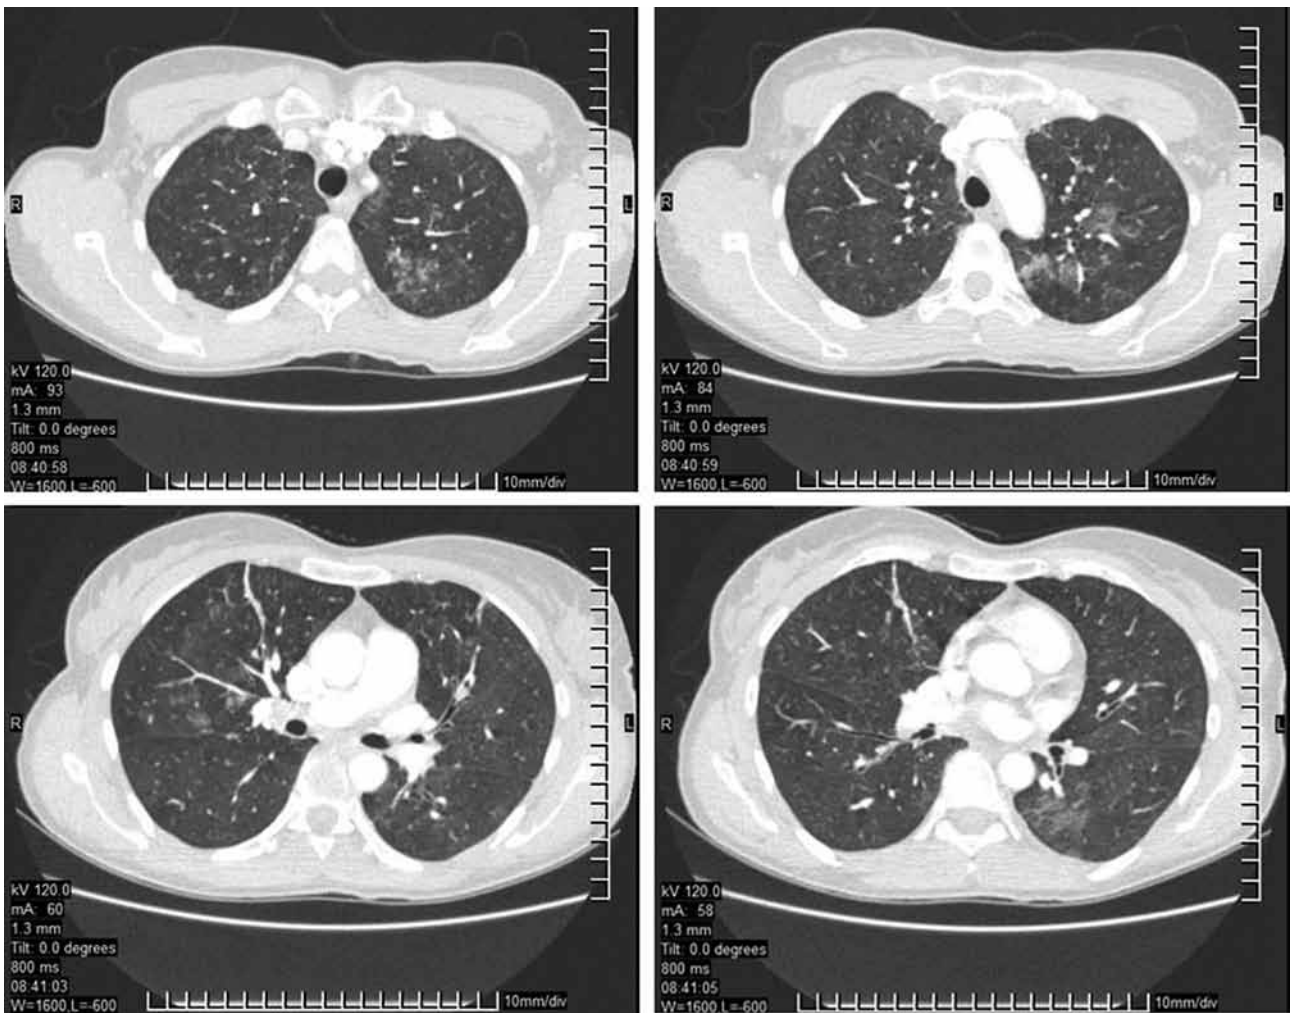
HRCT. Bilateral patchy ground-glass opacities.
